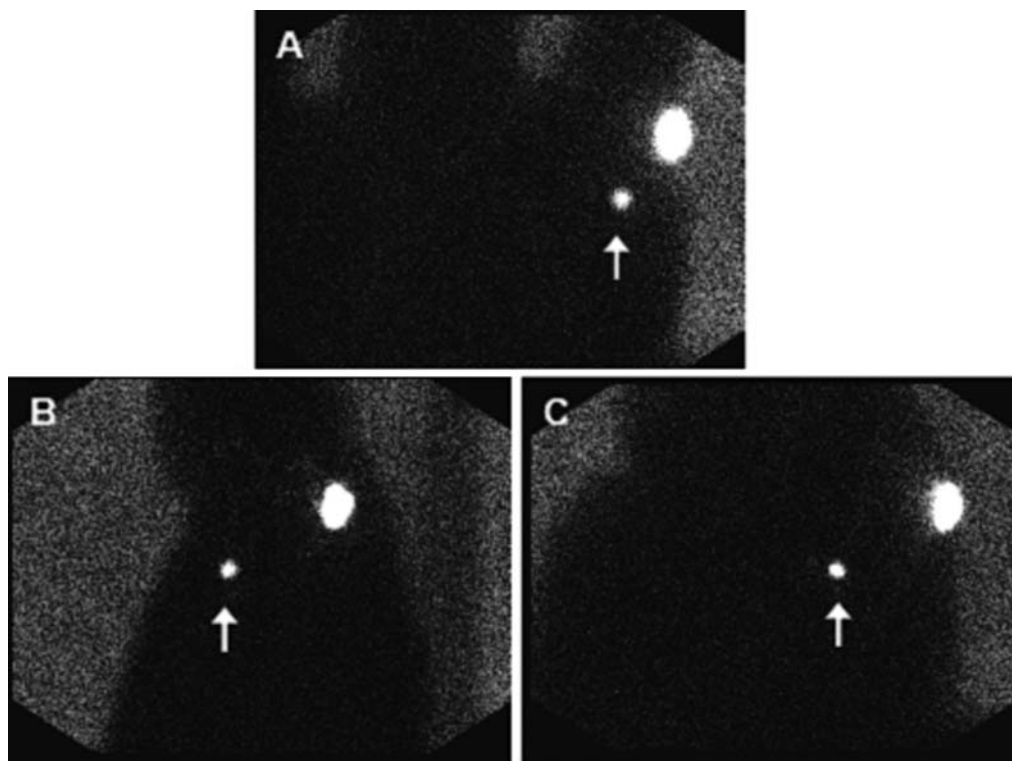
Lymphoscintigram of a melanoma patient after lymphoseek injection. The lymphoscintigraphic images were obtained in an anterior (Panel A), a left lateral (Panel B), and a left anterior oblique view (Panel C), showing one single sentinel lymph node (*Arrow*) next to the injection site of Lymphoseek in a melanoma patient at 2 hours postintra-dermal injection.
